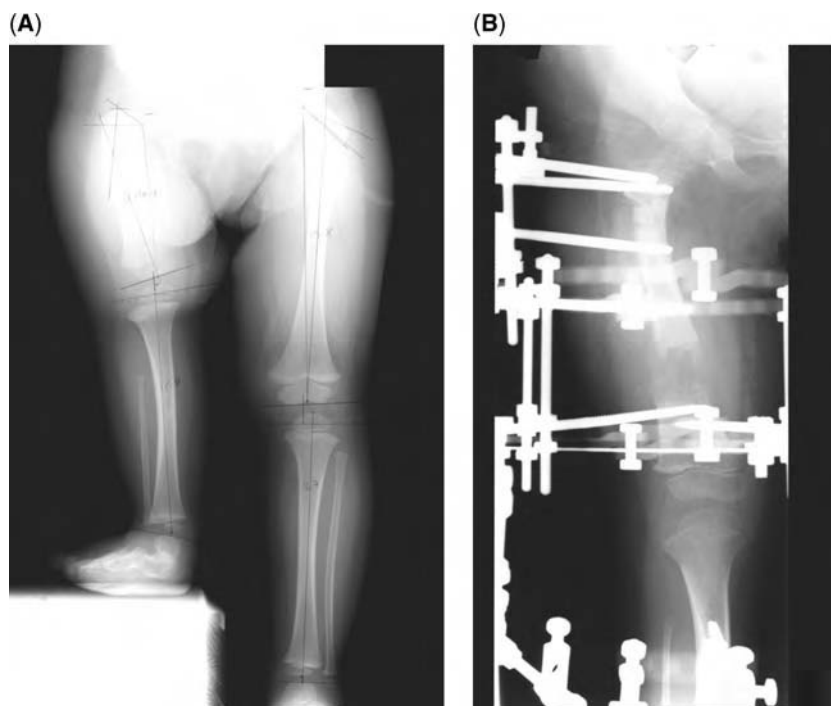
(A) Radiograph of patient with Paley Type 1a congenital femoral deficiency. The femoral neck is ossified and has significant coxa vara. (B) Radiograph shows initial lengthening with concurrent proximal subtrochanteric osteotomy for coxa vara correction. The lengthening is performed through the distal osteotomy site, and the external fixator bridges the knee joint to prevent subluxation and dislocation.
